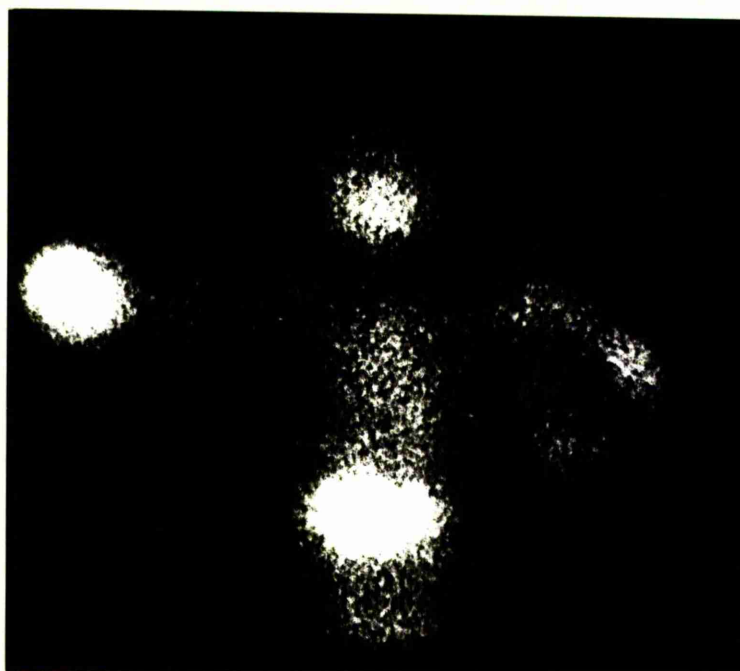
X-Ray Positive Metastases: Comparison
